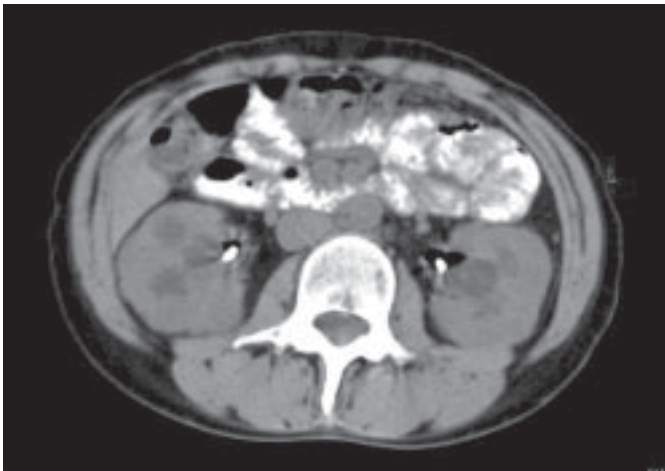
Abdominal computed tomography scan showing hydronephrosis in both kidneys.
